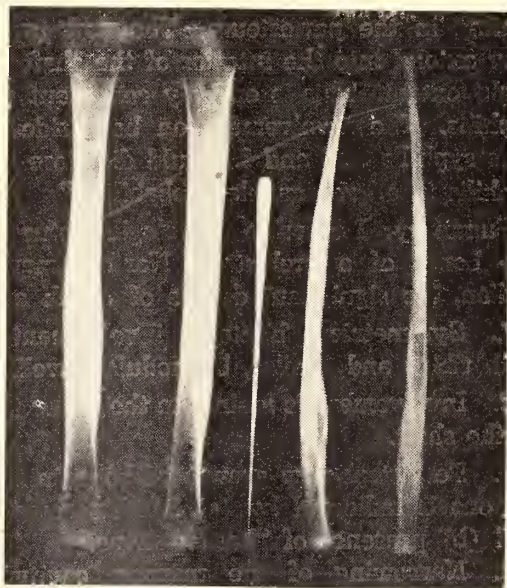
Roentgenogram of bones shown in Fig. I, with features similar to those described macroscopically. The increased density in the involved regions is apparent.
